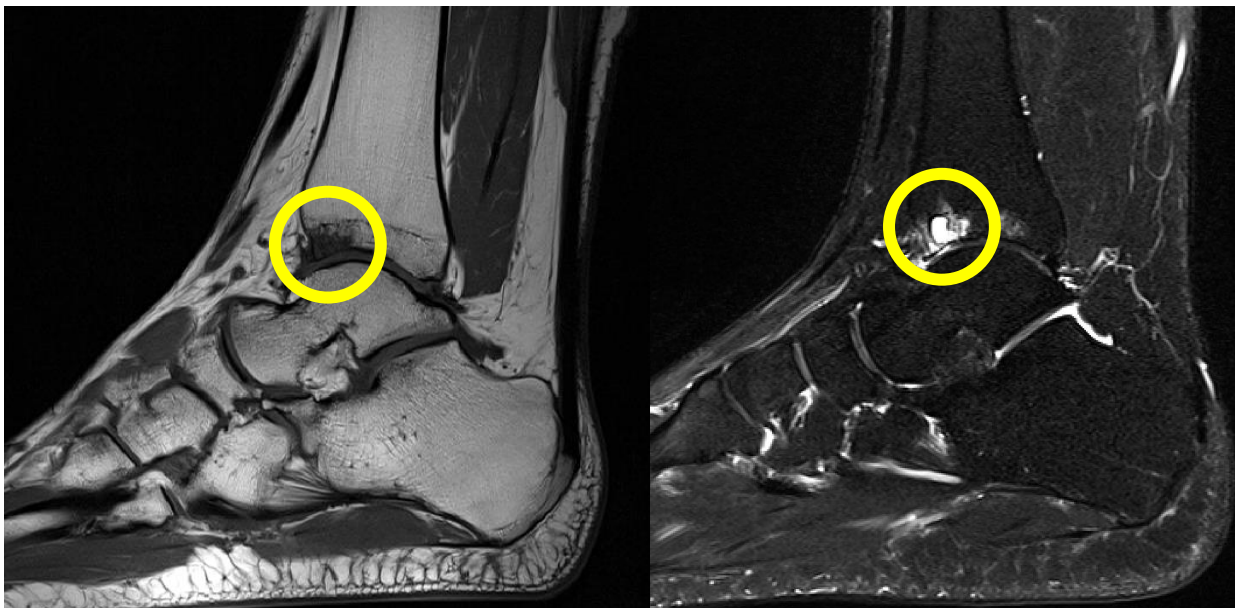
Subchondral bone cyst highlighted on T1 weighted MRI sequence (left) and T2 weighted MRI sequence (right)
